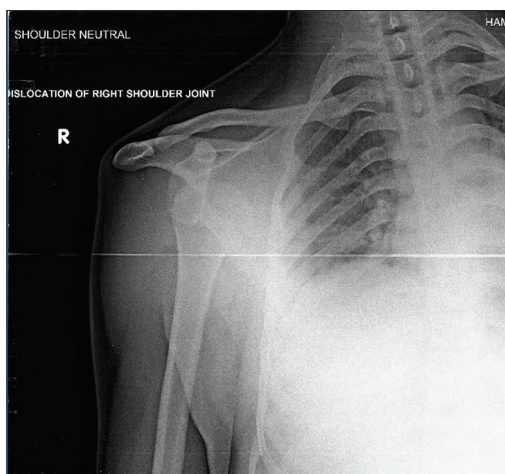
A-P radiograph right shoulder joint shows dislocation of humeral head posteriorly
